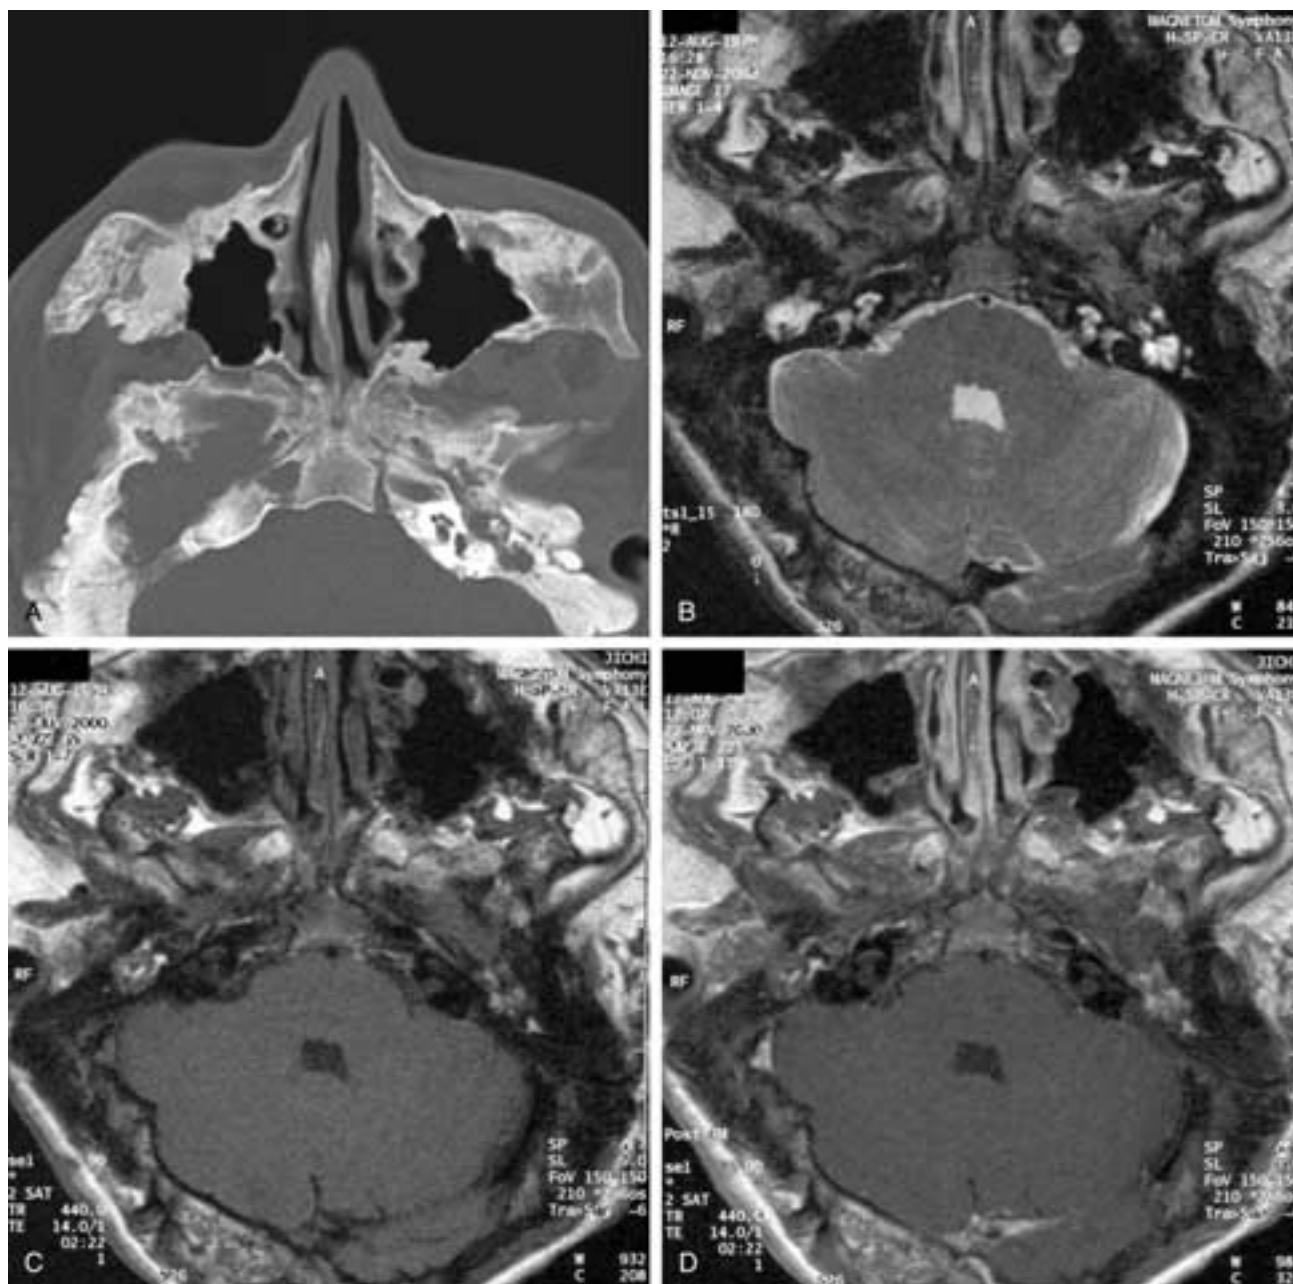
Frontometaphyseal dysplasia. A, Axial CT image demonstrates marked thickening and sclerotic change in the bony structures of the skull base including the temporal bone. B, Axial T2-weighted MR image shows fluid in the narrowed middle ear cavity on each side. The normal high signal of the labyrinth is preserved. C, Axial T1-weighted MR image shows a deformity and marked thickening of the bony structure in the inhomogeneous signal intensity of the bone marrow. D, Axial postcontrast-enhanced, T1-weighted MR image shows slight heterogeneous enhancement of the bony structures.
